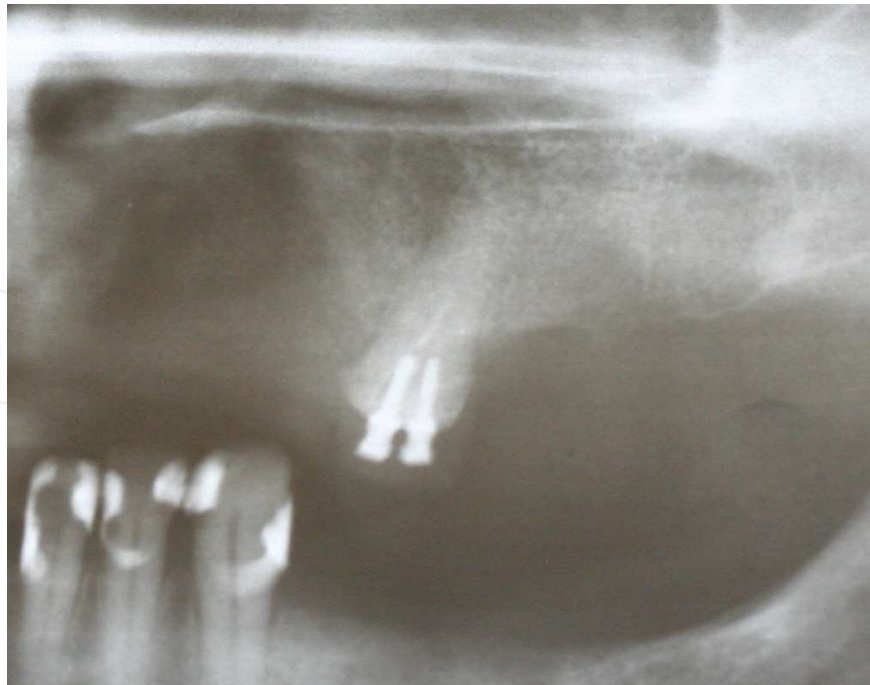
Osteolytic lesion in the periapical area of the tooth 25
